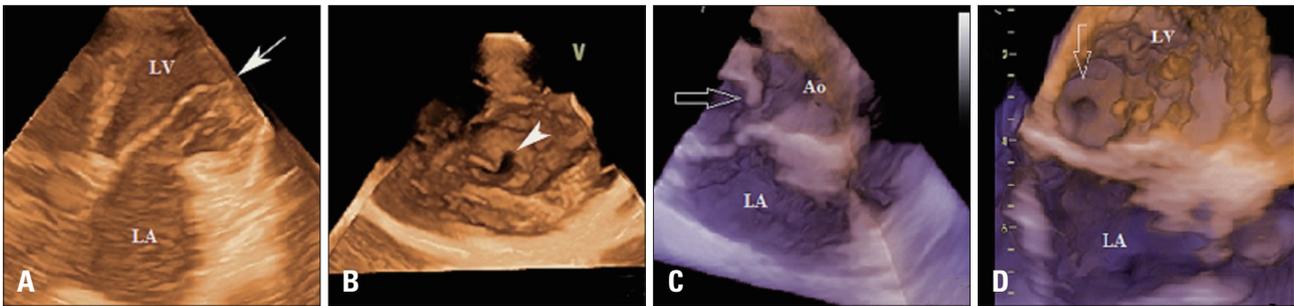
Three dimensional transthoracic echocardiography with color Doppler. The unifocal attachment of the parachute mitral valve can be clearly delineated in apical two chamber orientation (arrow in A). The sub valvular mitral stenosis was in fact caused by a slit like opening (arrowhead in B) in the parachute mitral valve. Parasternal long axis image in a systolic frame (C) clearly showing the sub aortic membrane (arrow in C). Three dimensional echocardiography clearly showing the anatomy of the sub aortic membrane (arrow in D) with a near circular membrane morphology and a central opening as viewed from the LV side. Ao: aorta, LA: left atria, LV: left ventricle.
